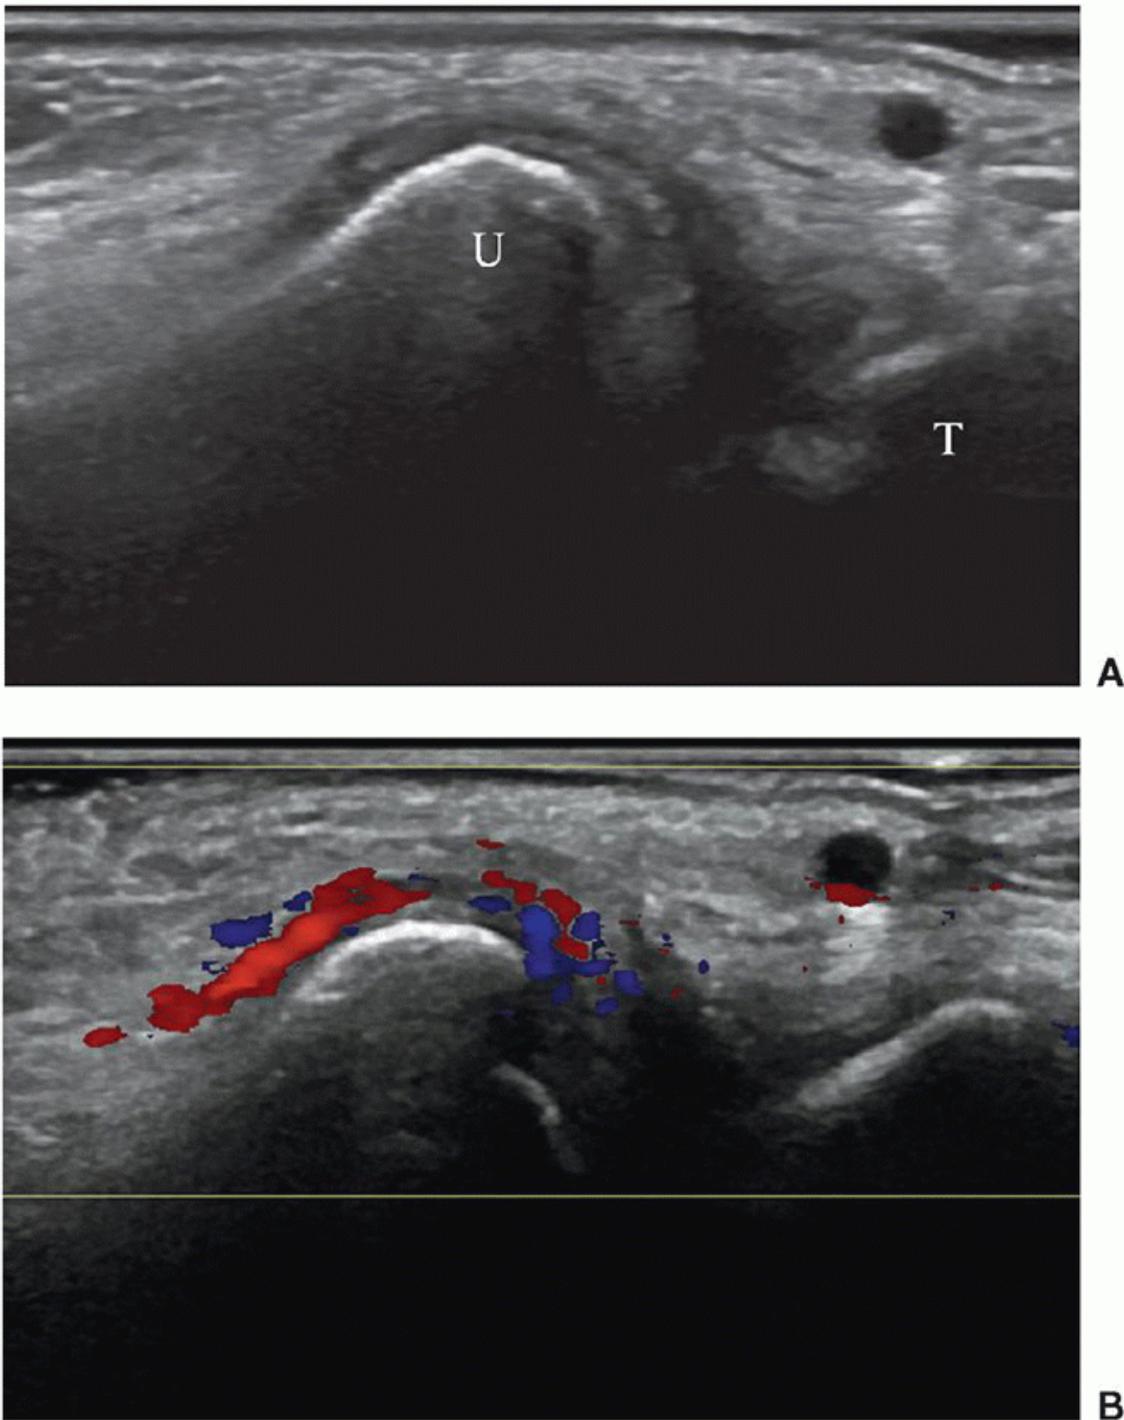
Rheumatoid arthritis patient. A: Hypoechoic synovial hypertrophy on ulnar aspect of wrist and around ulnar head (U). T, triquetrum. B: Synovial hyperemia around ulnar head on color Doppler examination is a sign of disease activity.
